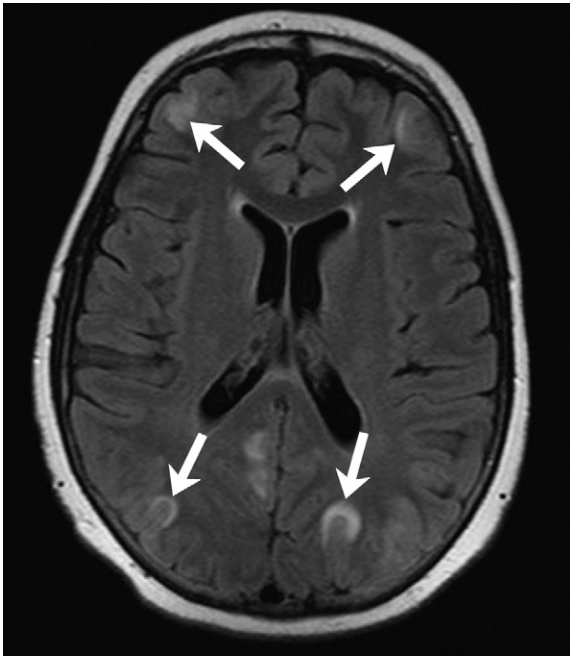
Posterior reversible encephalopathy syndrome. Axial FLAIR MRI showing subcortical foci of hyperintensity (arrows) associated with cyclosporin toxicity. Note that abnormalities may have a variable distribution and are frequently, but not always, posterior in location.
